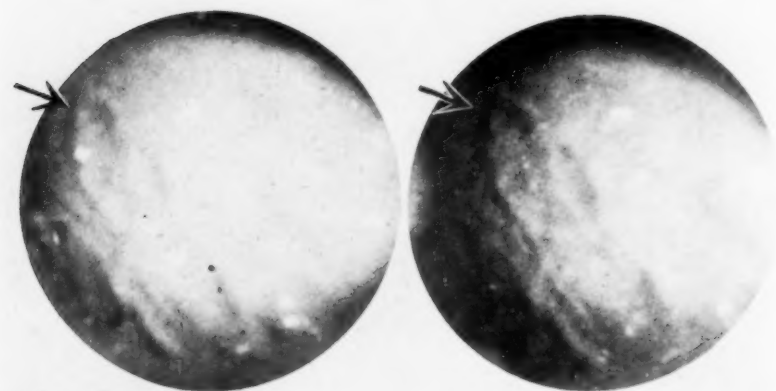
The X-ray pictures are indefinite, the fluoroscopic examination shows a distortion in the prepyloric region. The Gastro-photor pictures show an ulcer near the pylorus on the lesser curvature.
